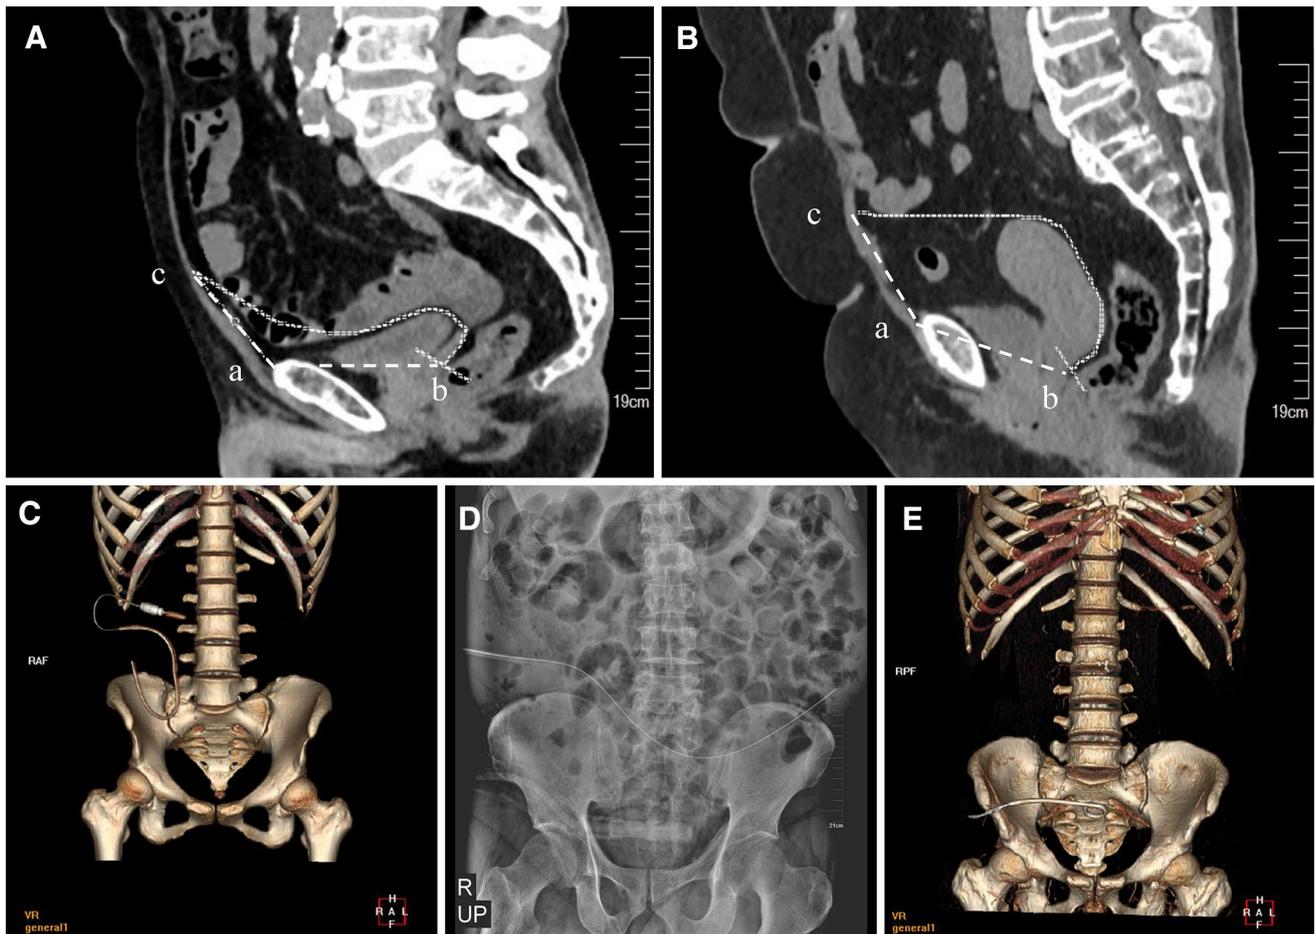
The optimal catheter insertion site and the common locations of the catheter tip after catheter migration in peritoneal dialysis. Distance from the pubic symphysis to the Douglas fossa (ab), and distance from the pubic symphysis to the optimal insertion site (ac) measured on a midline sagittal CT screenshot of a male patient and b midline sagittal CT screenshot of a female patient. c The
